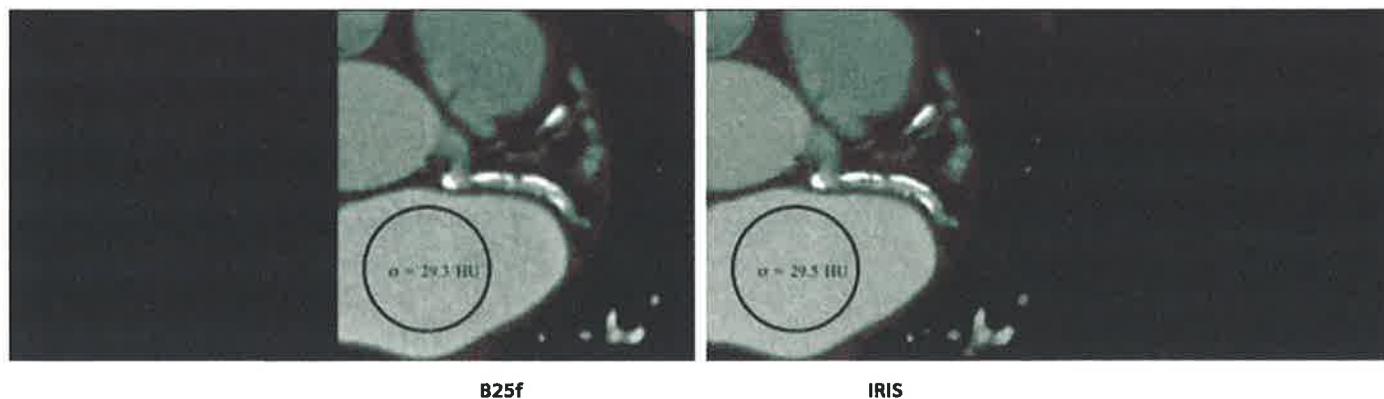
CT number (Hounsfield Units or HU) are unaltered when applying IRIS to images as demonstrated by the mean HU values between regions of interest in the original B25f kernel image on the left and the IRIS image on the right.
